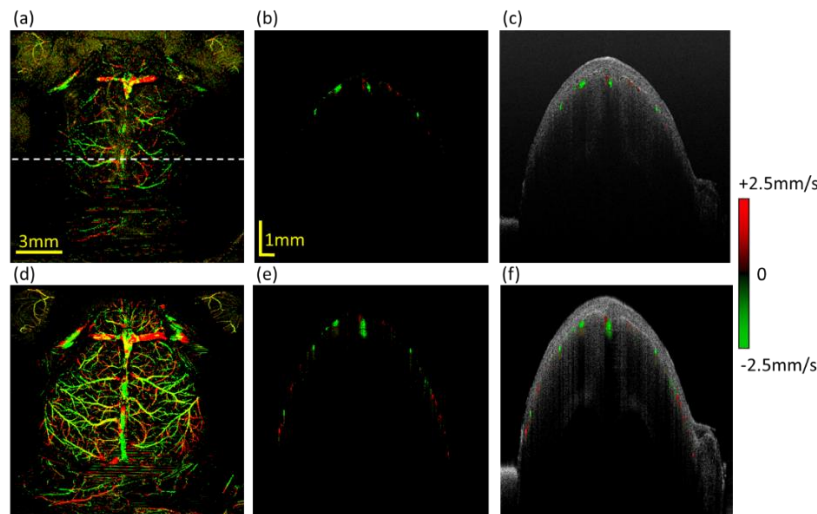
The comparison of wide-field DOMAG imaging of entire brain with cranium left intact between SD-OCTA system (top row) and UW-OCTA system (bottom row). (a) and (e) are the *en face* Doppler cerebral vascular images. (b) and (c) are the cross-sectional Doppler flow image overlaid with structural image at the position indicated by the white dash line in (a) by SD-OCTA. (f) and (g) are the corresponding comparison pairs at the position indicated by the white dash line in (d) by SS-OCTA.
